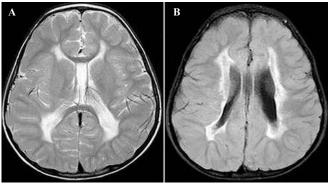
Leukomalacia/gliosis with ventricular enlargement and volume loss at transverse T2-weighted fast spin-echo MR (A) and transverse fast fluid-attenuated inversion recovery (FLAIR) MR images (B). MR = magnetic resonance.
